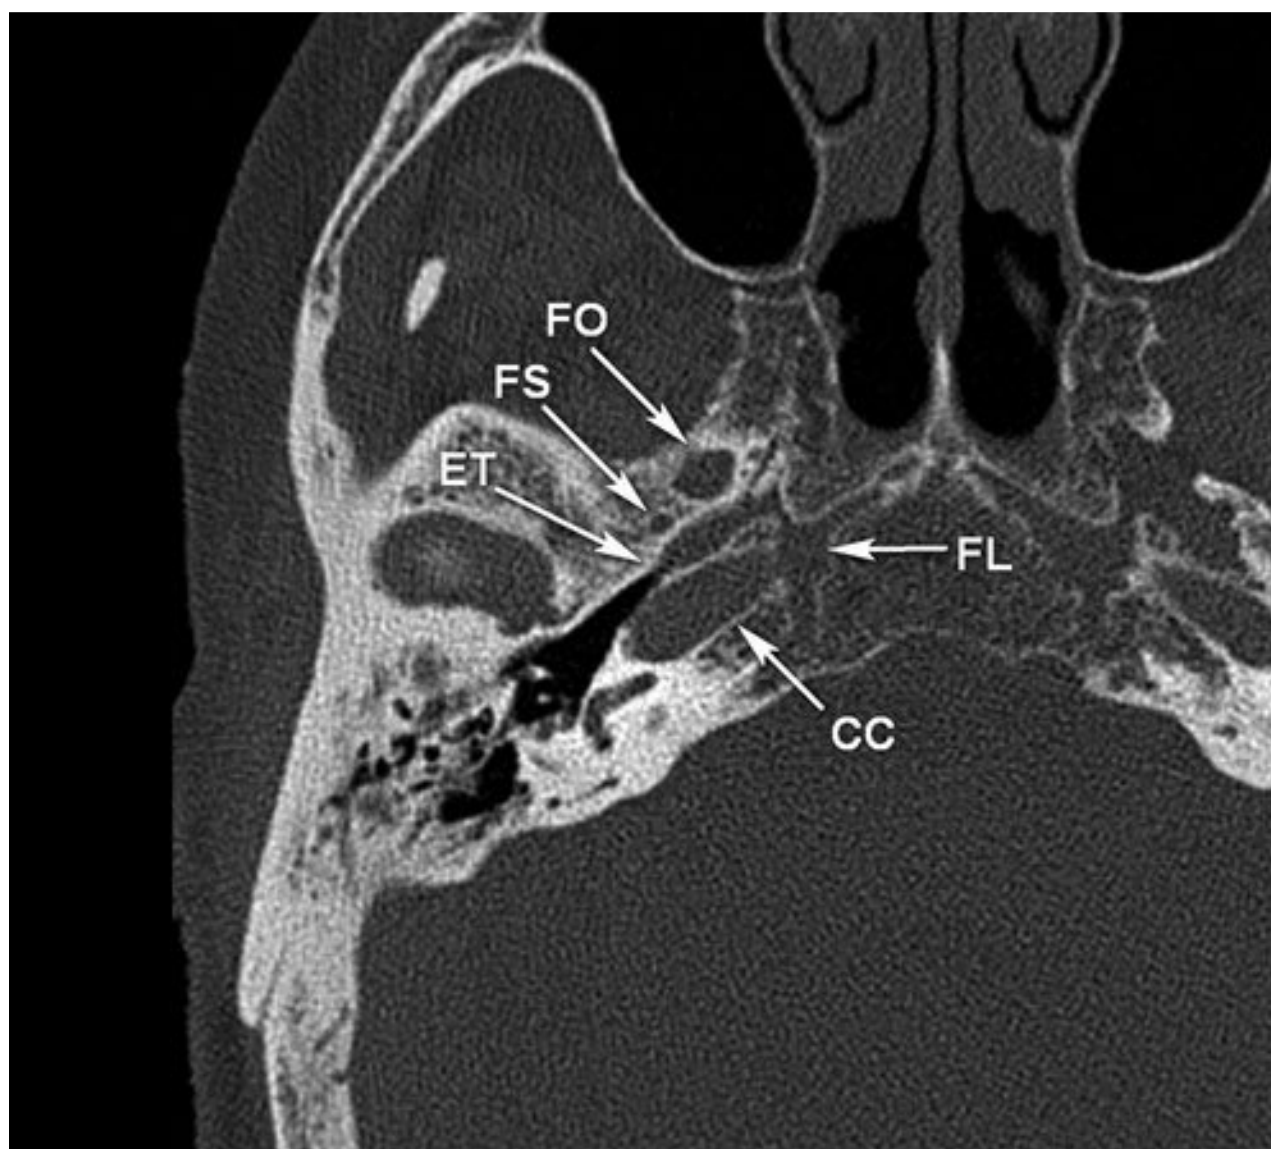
Axial computed tomographic image through the skull base demonstrates the relationships between various foramina, fissures, and canals along the lateral margin of the central skull base region. The internal carotid artery passes obliquely through the carotid canal (CC) and exits the canal just above cartilage-filled gap, the foramen lacerum (FL). The eustachian tube (ET) consists of bony and cartilaginous segments and passes both medially and inferiorly from the middle ear to the nasopharynx. Note the intimate relationship between the eustachian tube, the carotid canal and the foramen spinosum (FS).
